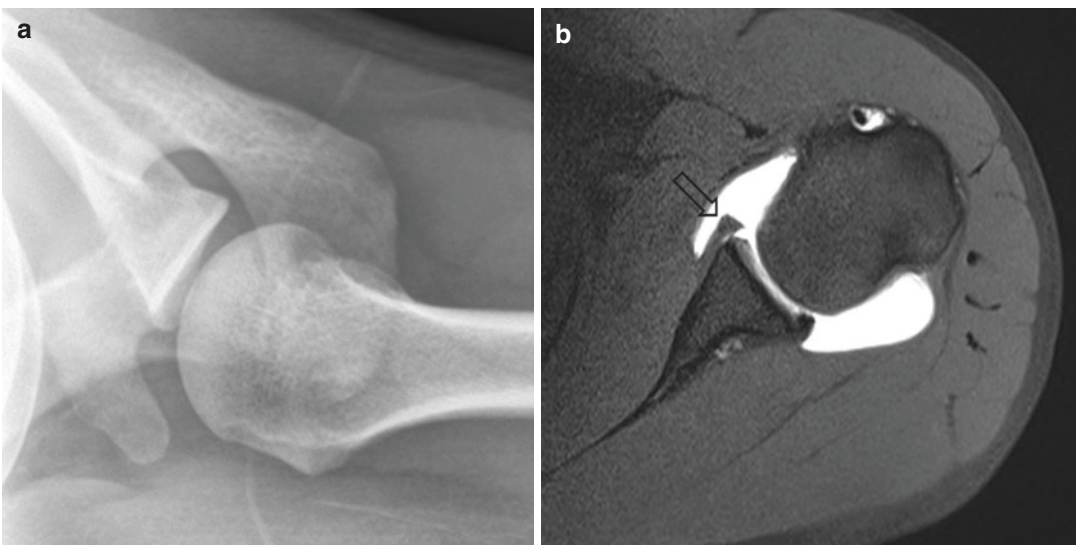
A 22-year-old man who had recurrent episodes of anterior shoulder dislocation. (a) Axillary radiographic view of the left shoulder shows normal joint alignment and no significant osseous abnormality. (b) Axial fat-suppressed T1-W MR arthrographic image of the left shoulder shows a Perthes lesion (a variant of the Bankart
